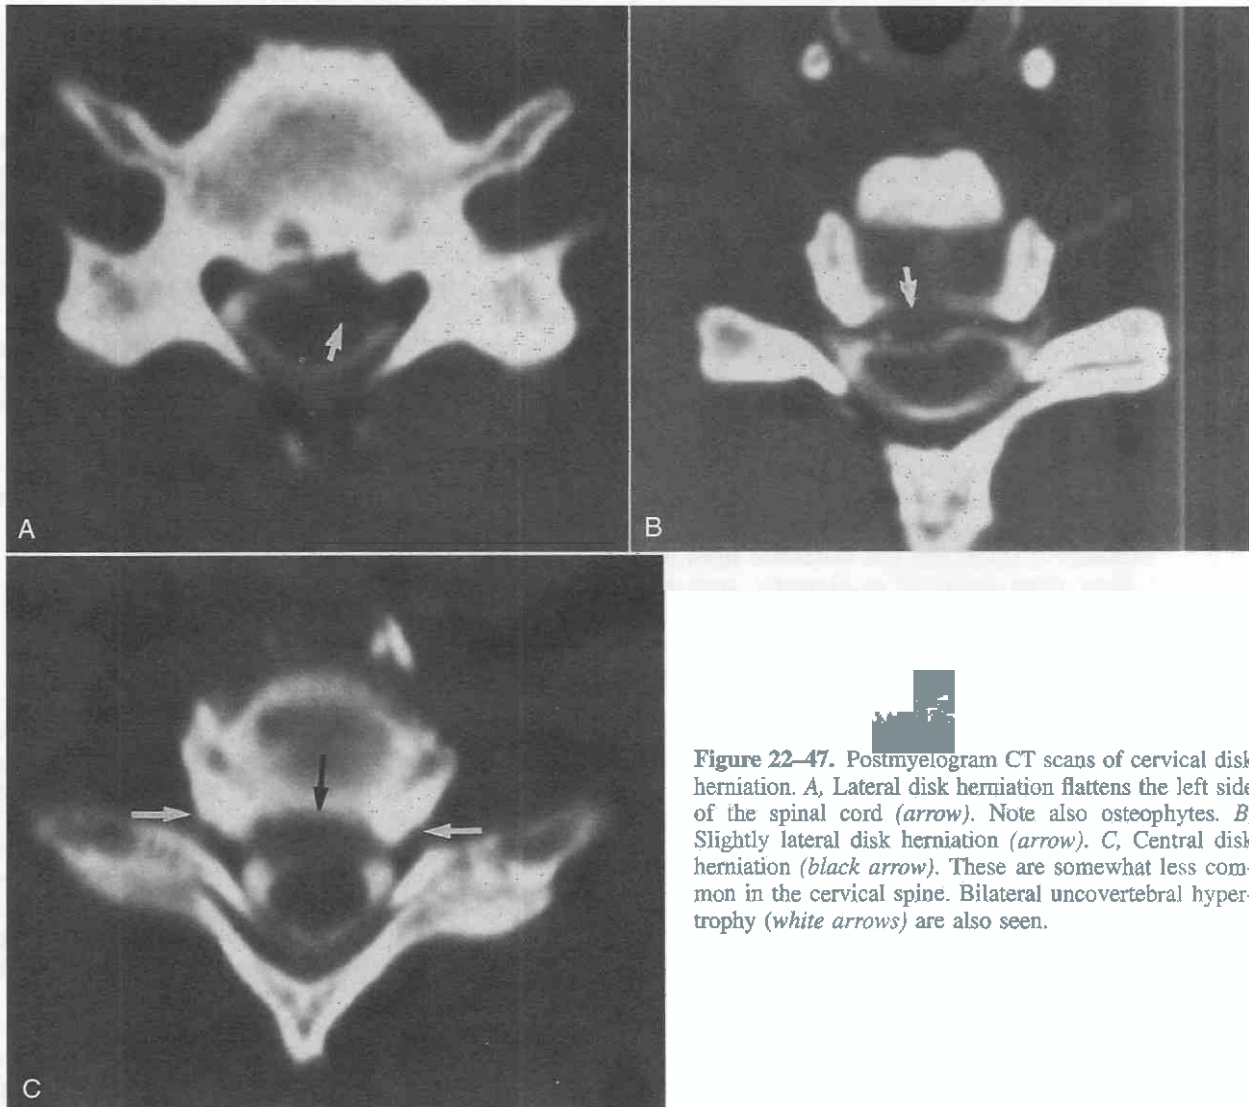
Postmyelogram CT scans of cervical disk herniation. A, Lateral disk herniation flattens the left side of the spinal cord (arrow). Note also osteophytes. B, Slightly lateral disk herniation (arrow). C, Central disk herniation (black arrow). These are somewhat less common in the cervical spine. Bilateral uncovertebral hypertrophy (white arrows) are also seen.
